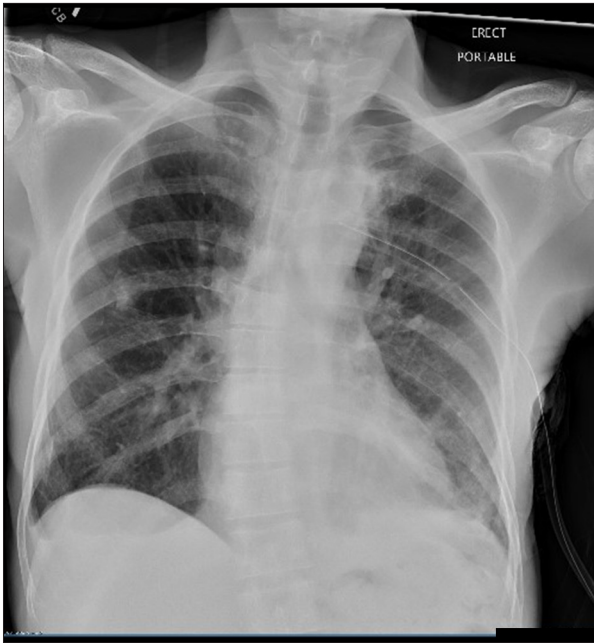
Chest X-ray showing resolution of the pneumothorax after chest tube placement.
